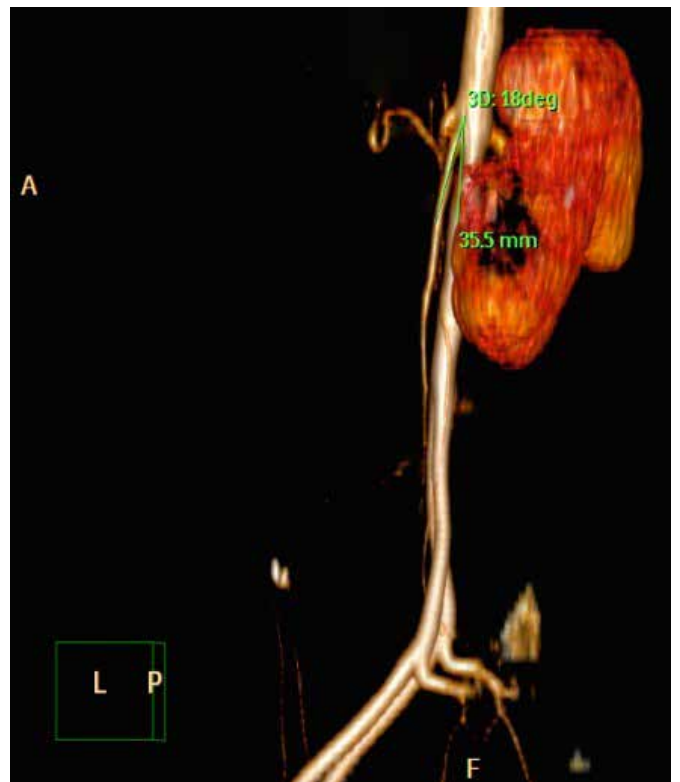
3D sargital cut CT showing aorto-mesenteric angulation of approximately 18 o.
